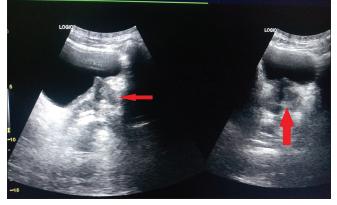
Longitudinal and transverse ultrasound image of the prostate gland (red arrows) posterior to the bladder
